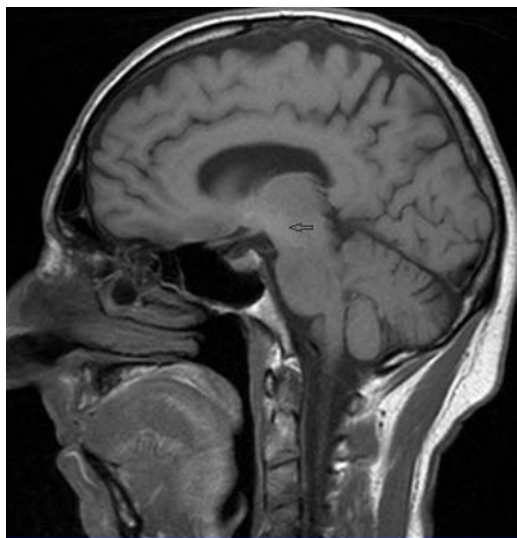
T1-weighted MRI image of brain (sagittal section) showing hyperintensity in substantia nigra (arrow).
